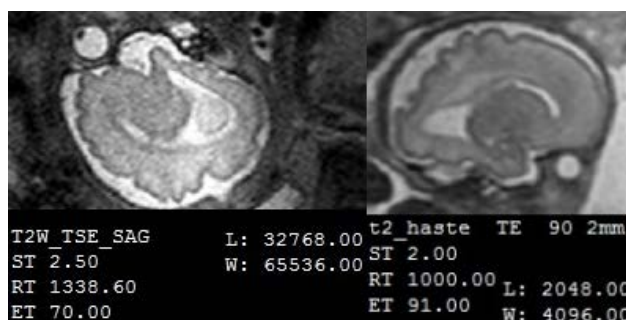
Magnetic Resonance Imaging: left: 1.5T=212; right: 3T=216 | Both images are wrapped in 16-bit DICOM container, but more stored-bit values were higher in 3T images.
